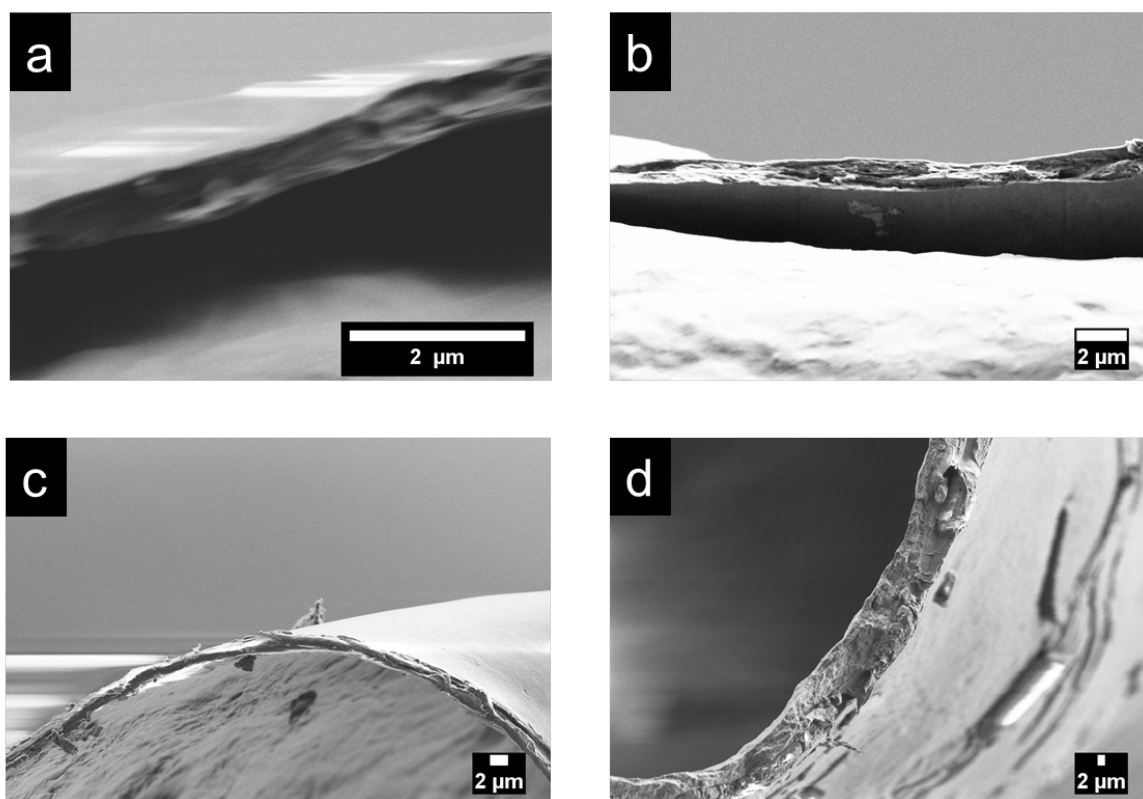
SEM pictures of AL/CH + metronidazole + TPP coating fabricated by means of a dual feed ultrasonic spray coater: a) 10 passes, b) 20 passes, c) 30 passes and d) 45 passes.
